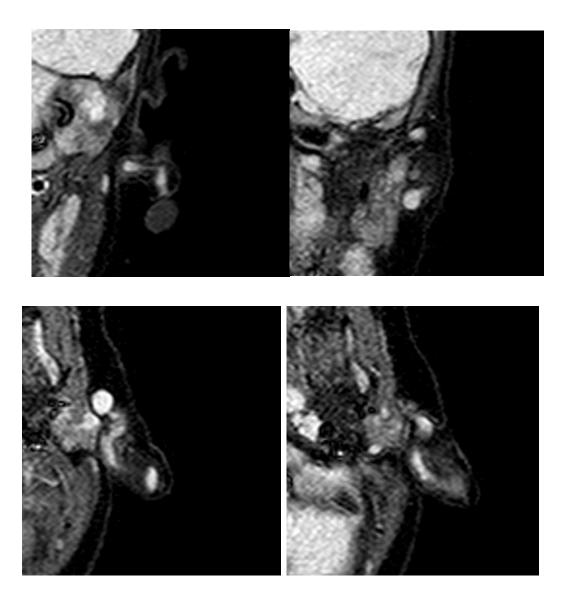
Coronal STIR (top left and right) and Axial STIR (bottom left and right) MRI images of patient C. MRI showed a serpiginous cystic space extending from the left earlobe (white arrow) passing deep coursing beneath the external auditory meatus to preauricular region (white triangle)
